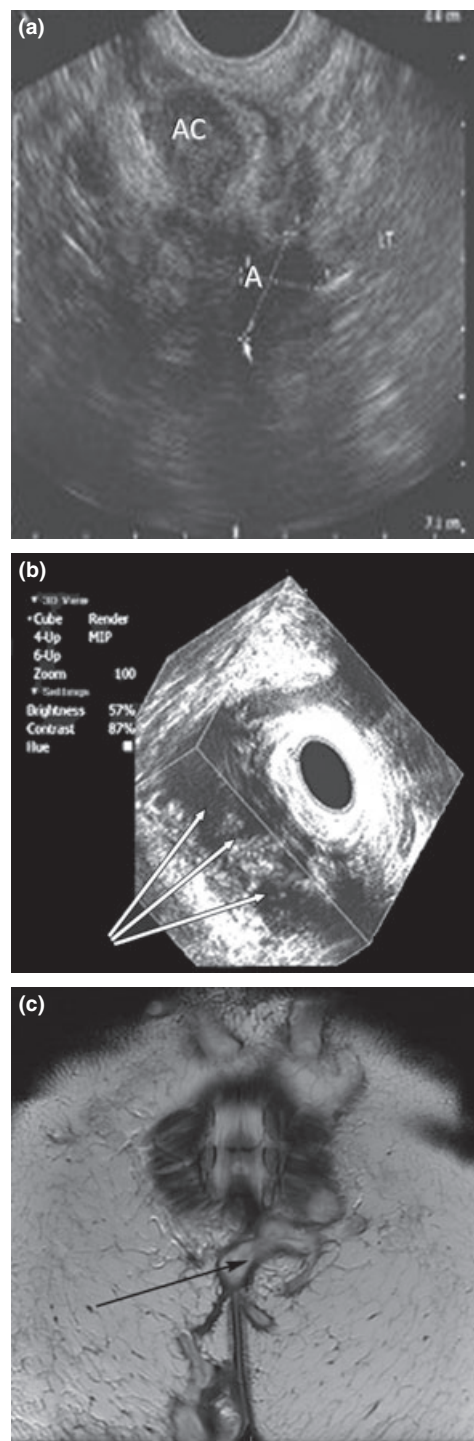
(a) Horseshoe abscess (axial transperineal ultrasound image). The anal canal (AC) with the hypoechoic internal anal sphincter is shown with the abscess posteriorly located (A). (b) The corresponding three-dimensional endoanal ultrasound view showing an extensive horseshoe abscess (arrows) in a patient with perianal Crohn's disease. (c) The corresponding MRI (T2 FSE) view of the extensive horseshoe collection (arrow).
